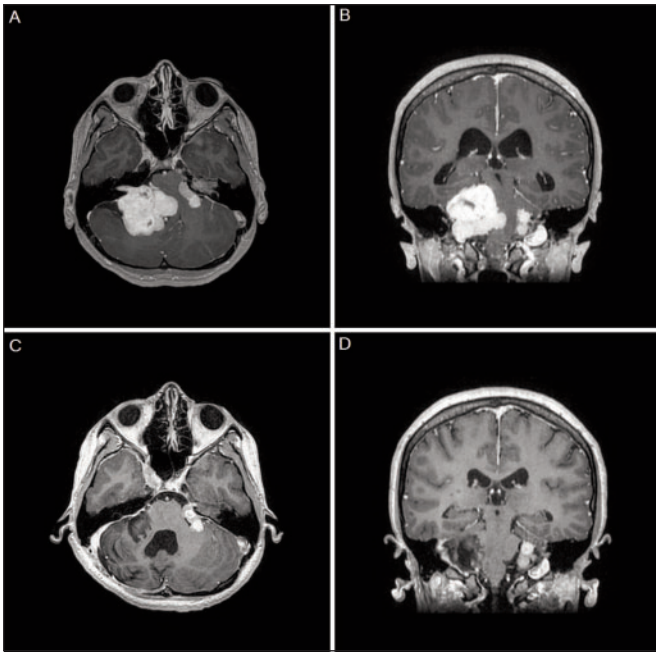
Axial (A) and coronal (B) enhanced T1-weighted magnetic resonance imaging scans demonstrating the presence of two cerebellopontine angle tumors (4.4 x 4.2 cm on the right compared with 2.3 x 1.8 cm on the left). (C) and (D), postoperative scans showing near total resection of the right vestibular schwannoma with no evidence of complications.
